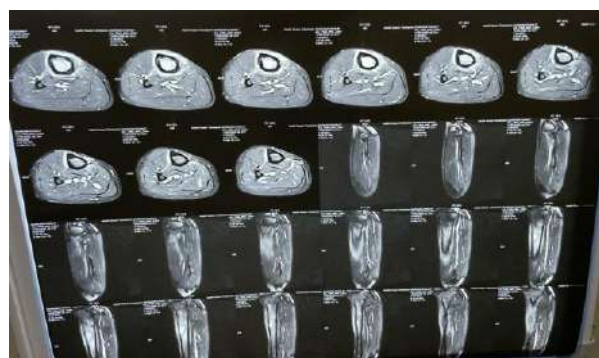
2 ABCD MRI T2WI and STIR images in the coronal and axial sections shows a well defined hyperintense lesion with hypointense margin noted in the midshaft of the tibia. Surrounding intramuscular edema noted.
